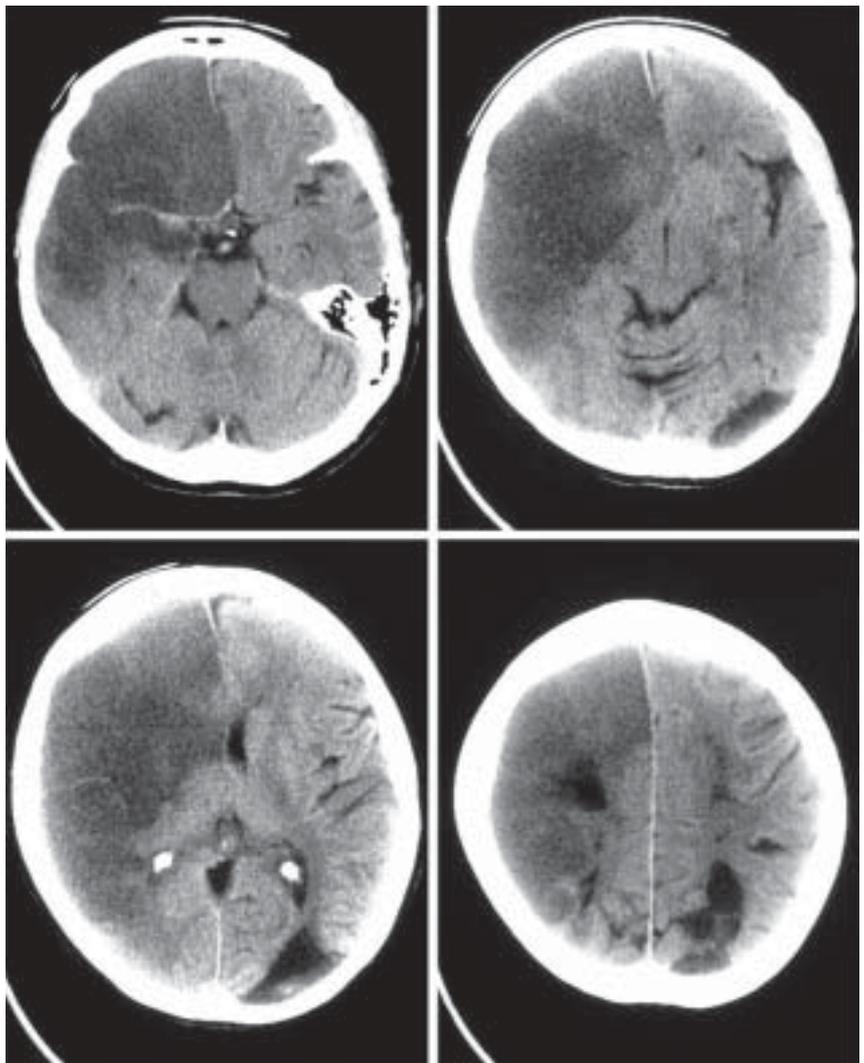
Non-contrast CT scan demonstrating acute infarction in the right frontal and anterior temporal lobes with mass effect.
